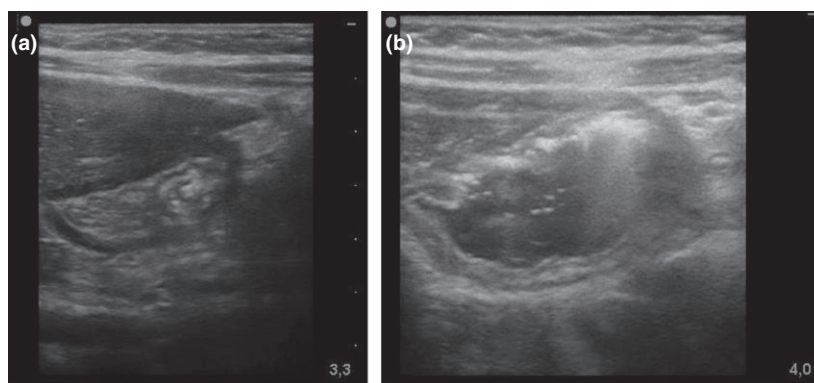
Ultrasound images of a child with Perlas grade 1 stomach contents. (a) empty antrum in the semirecumbent position (b) dilated antrum with anechoic fluid content in the right lateral decubitus position.
